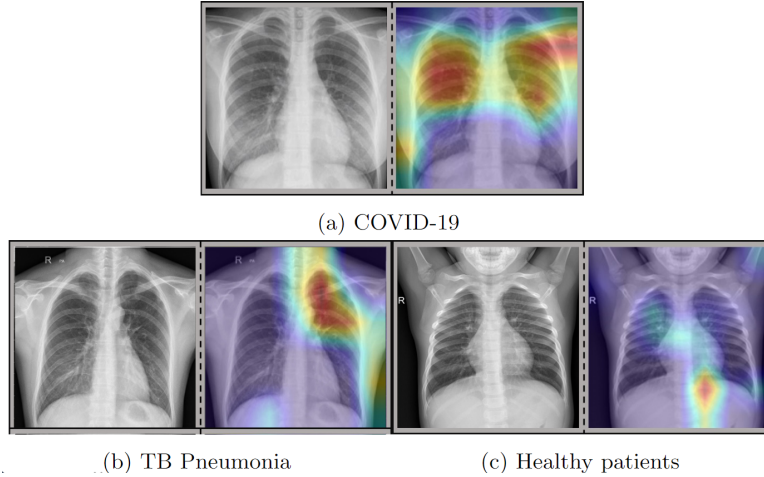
Visual example of achieved results. For each diagnostic class, we show the raw Chest X-ray image (left) and Grad-CAM result (right). Images on the right sides highlight the most important areas involved in the classification process.
